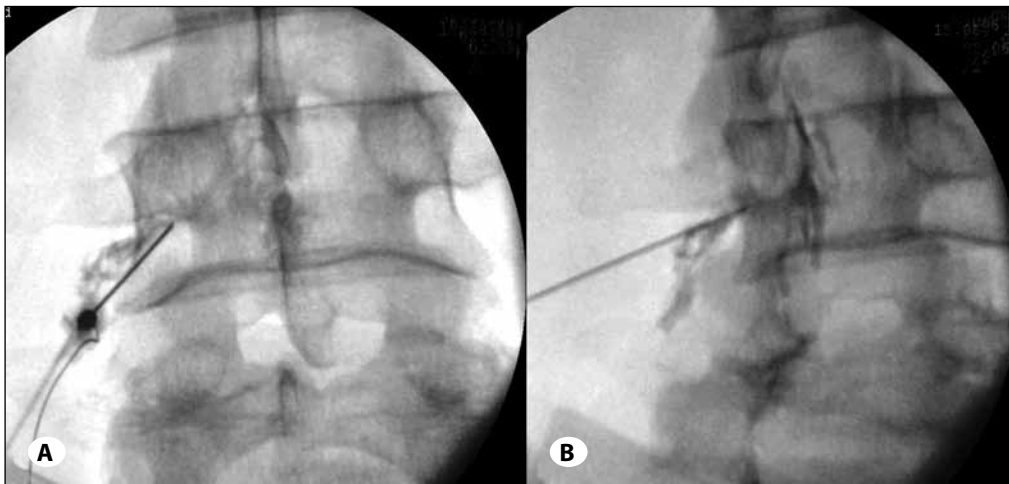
Upon confirmation of reaching the intended injection site, posteroanterior and oblique spot radiographs were obtained to document distribution of the contrast material. The landmark for needle insertion was slightly lateral to the pars interarticularis on the oblique view, and at the neural foramen near the nerve root impingement site at the supra adjacent disk level on the posteroanterior (A) and oblique (B) view.
